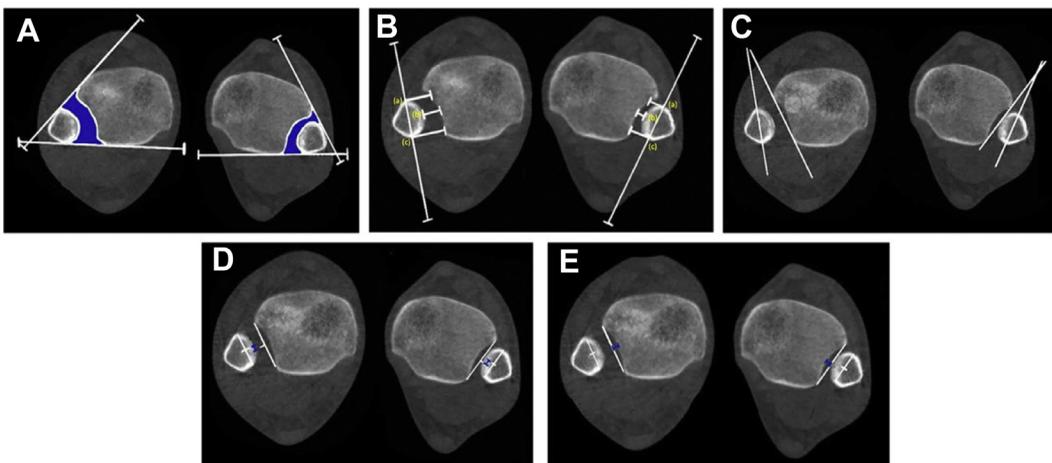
Tibiofibular joint measurements. (A) Syndesmotomic area (shaded area). (B) Direct anterior (a), middle (b), and direct posterior (c) differences. (C) Fibular rotation. (D) Sagittal translation (dark line). (E) Incisura depth (dark line). The patient had right-sided syndesmosis instability after an acute posterolateral ankle dislocation. (From Hage-meijer NC, Chang SH, Abdelaziz ME, et al. Range of Normal and Abnormal Syndesmotomic Measurements Using Weightbearing CT. *Foot Ankle Int*. 2019;40(12):1430-1437. <https://doi.org/10.1177/1071100719866831>; with permission.)
